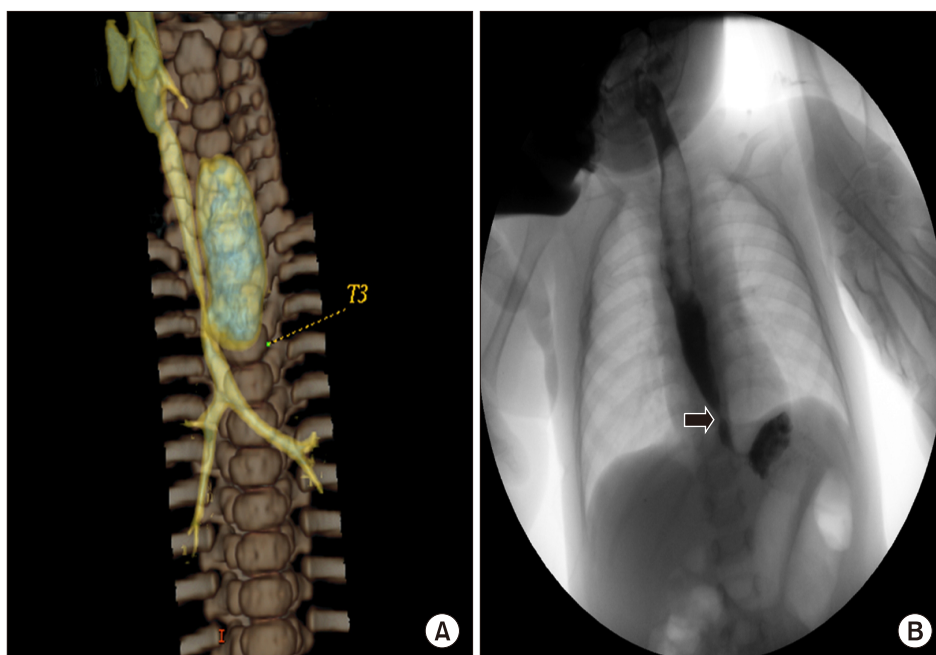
(A) Reconstructed computed tomography before the first end-to-end anastomosis for esophageal atresia. (B) The esophagogram showed a tapered narrowing 2-3 cm above the cardia (an arrow indicates the narrowing lesion).
